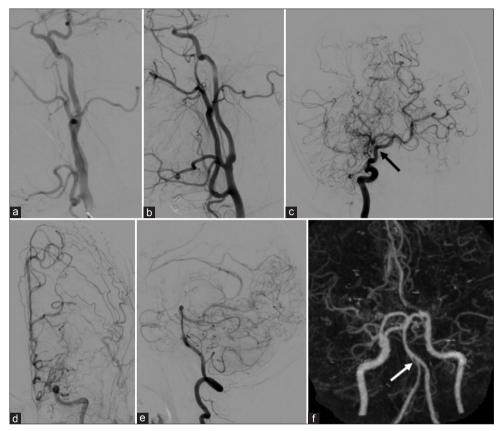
(a and b) Common carotid angiograms showed that bilateral facial artery, lingual artery, and superior thyroid artery originated from the ipsilateral common carotid artery; (c and d) internal carotid angiograms showed the complete occlusion of both middle cerebral arteries and the formation of moyamoya vessels and a persistent primitive trigeminal artery (black arrow); (e) left vertebral artery angiogram showed the collateral circulation established from the posterior circulation to the anterior one; (f) computed tomography angiography showed the fenestration of the basilar artery (white arrow).
